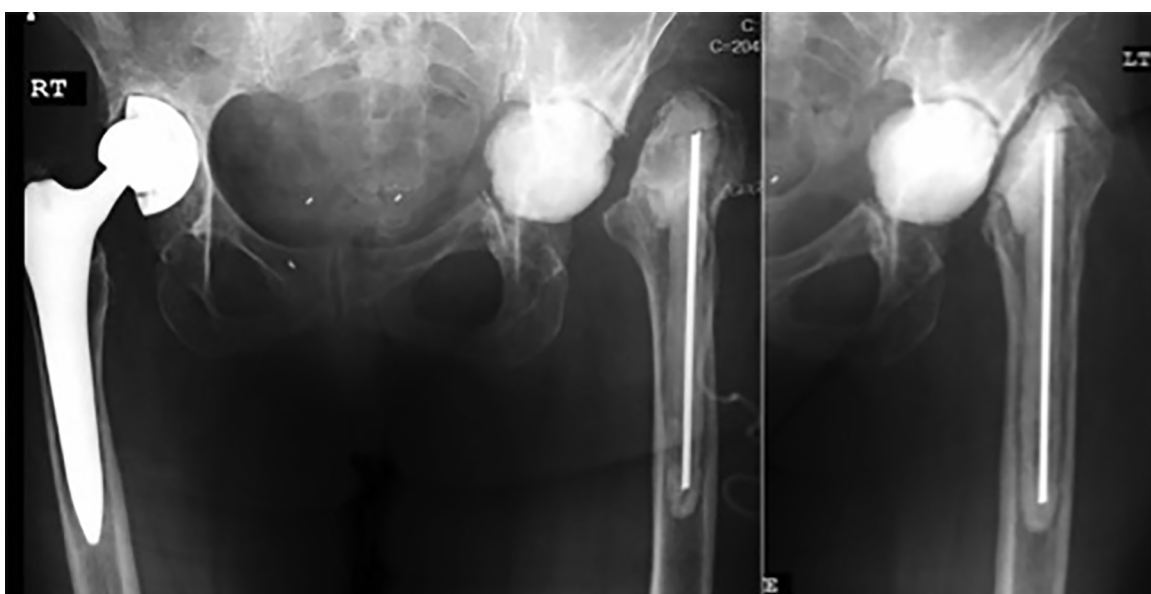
Pelvic AP radiograph and Frog-lateral of the left hip status post left hip explant and placement of a static antibiotic cement spacer. A Hickman's catheter was placed for intra-articular antibiotic delivery.
